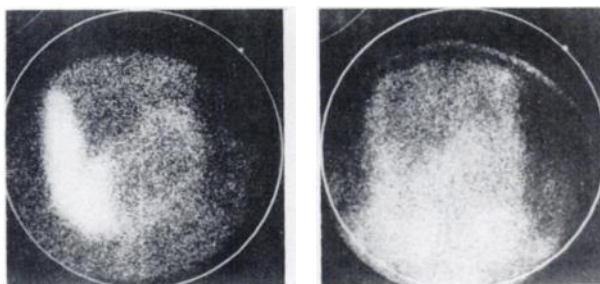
Case 1. Technetium-99m-pertechnetate thyroid scintigraph (left) shows cold mass in left lobe. Indium-113m perfusion image (right) shows good perfusion of corresponding cold lesion (follicular adenoma).
